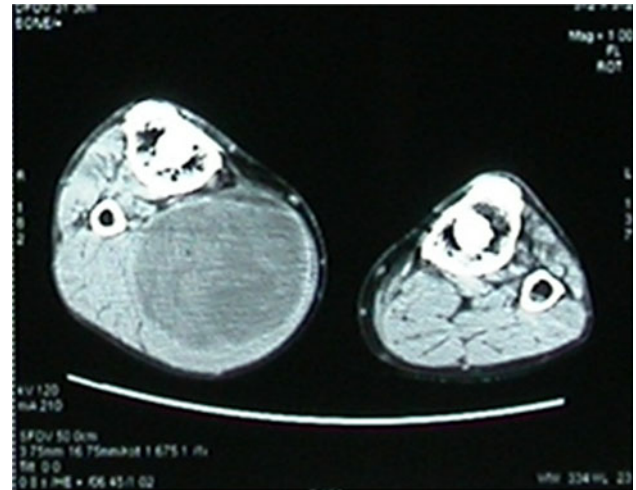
Computed tomography shows a well-defined paratibial cystic mass over the right proximal leg
